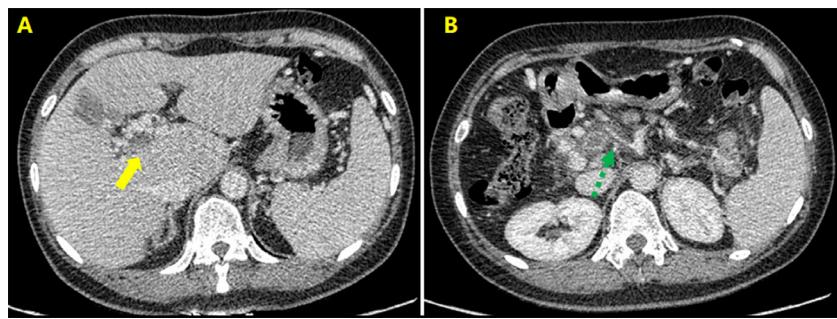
Computed tomography scans performed on August 6, 2021, at admission. Computed tomography showed portal vein thrombosis (solid arrow) (A) and superior mesenteric vein thrombosis (dotted arrow) (B).
